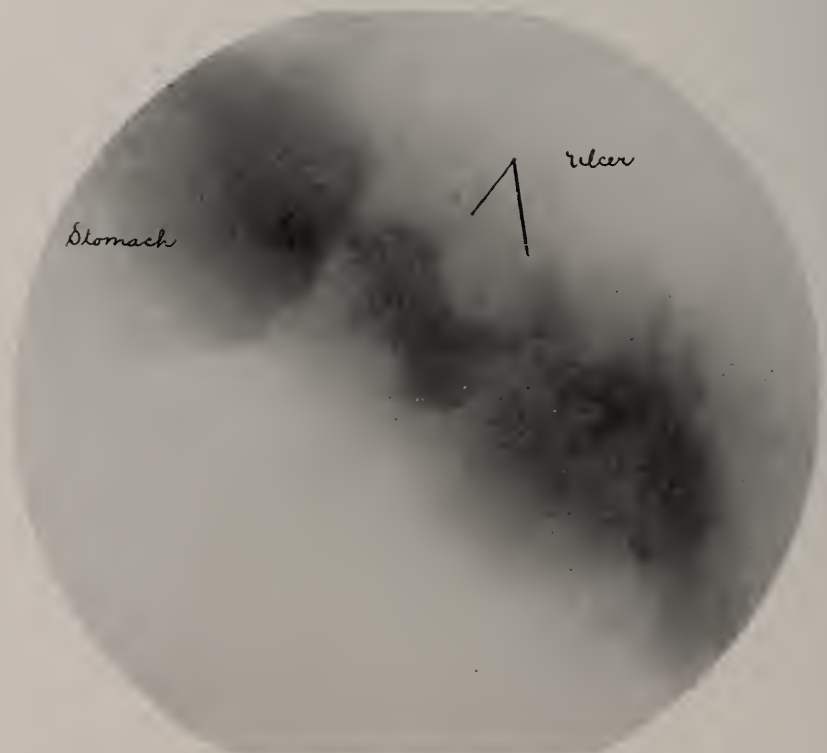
Shown with an apology. Lateral view of man weighing over two hundred pounds. Numerous plates taken on different days show a persistent defect. Roentgen diagnosis: "Cicatrix of ulcer on posterior-superior surface of first portion of duodenum." Operation showed old ulcer of first portion, on superior surface, extending as much anteriorly as posteriorly.
